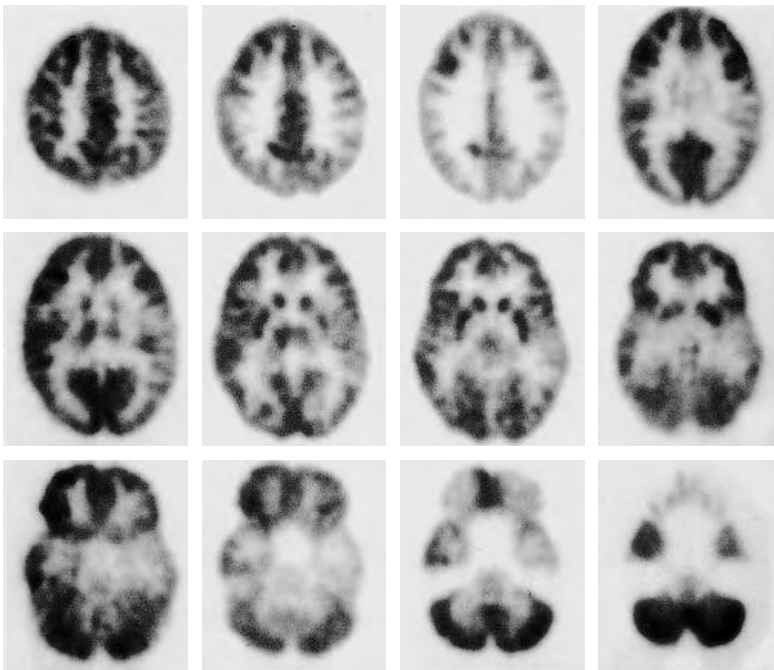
^{18}F -FDG-PET images of a patient with partial complex epilepsy. There is left temporal lobe interictal hypometabolism corresponding to the left temporal lobe seizure focus. In addition, the area of hypometabolism extends into the left frontoparietal region and ipsilateral thalamus, even though these areas were normal on the electroencephalogram
